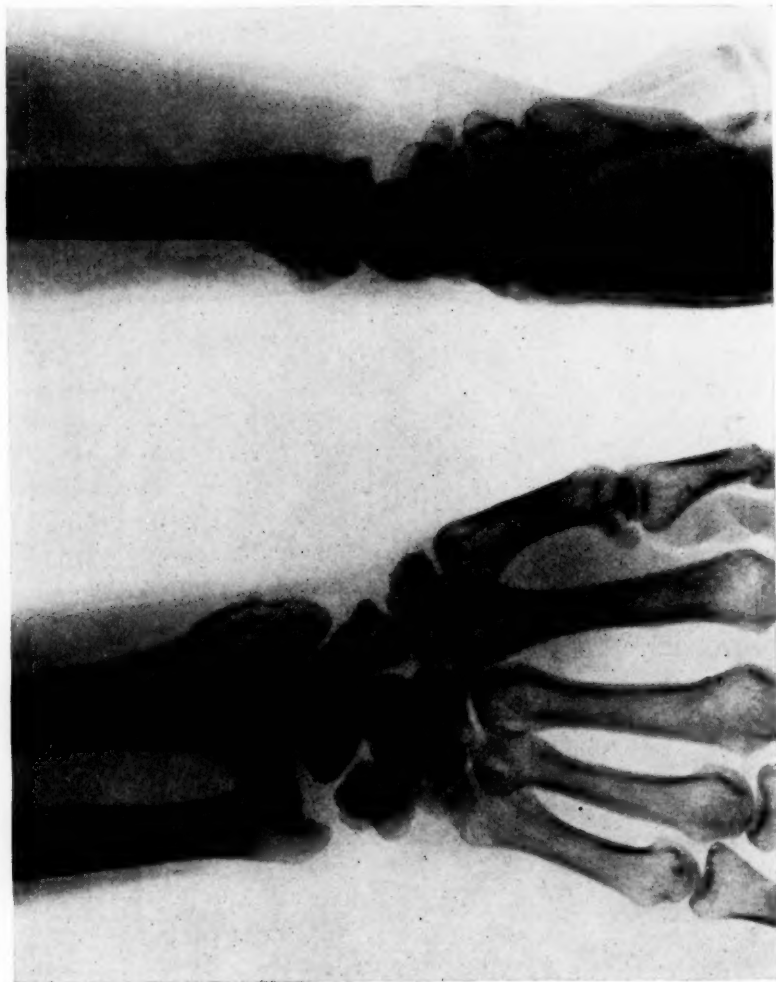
Radiograph showing X-shaped fracture of left wrist caused by recoil of handle of motor-boat engine.
